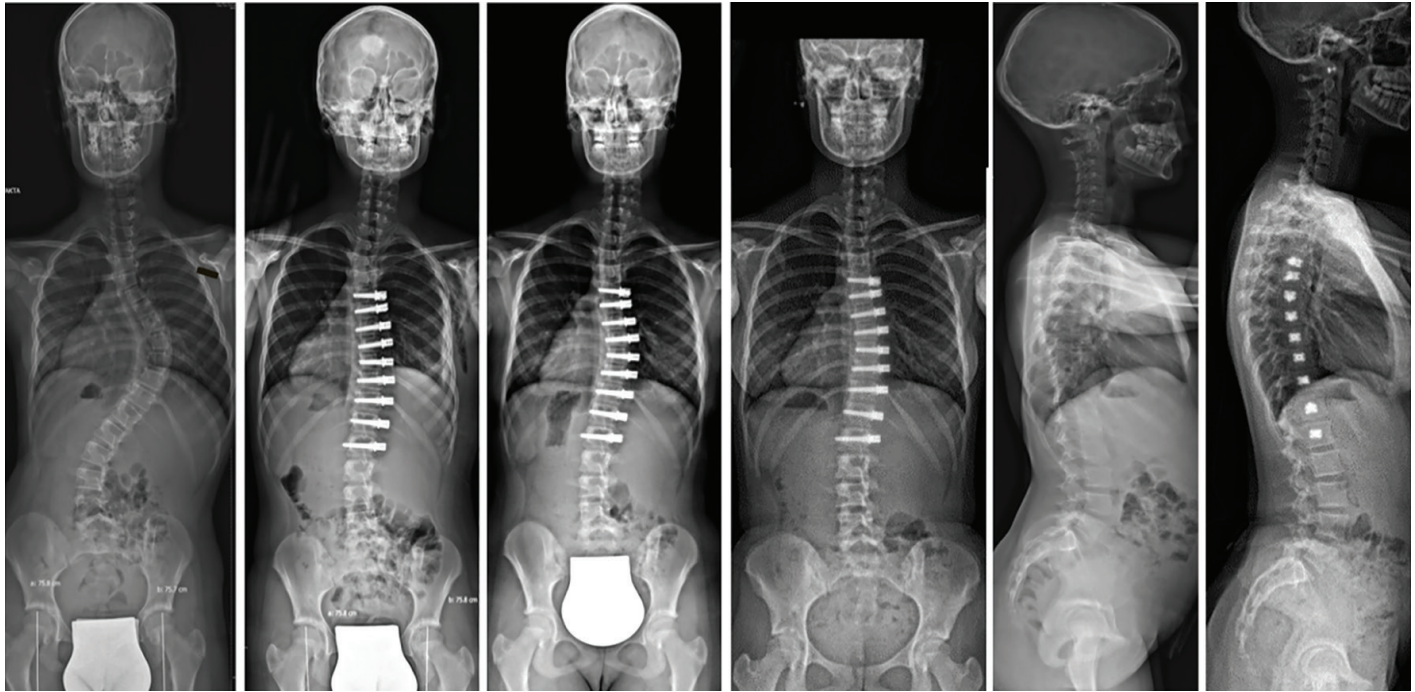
Standing whole-spine radiographs of a skeletally immature patient treated with VBT for a 70° main thoracic curve. Early postoperative AP radiograph shows residual deformity, which gradually remodels to 8° at 3-year follow-up. Lateral radiographs demonstrate improvement of thoracic kyphosis from 15° to 33° with preserved global sagittal alignment. VBT: Vertebral body tethering, AP: Anteroposterior
